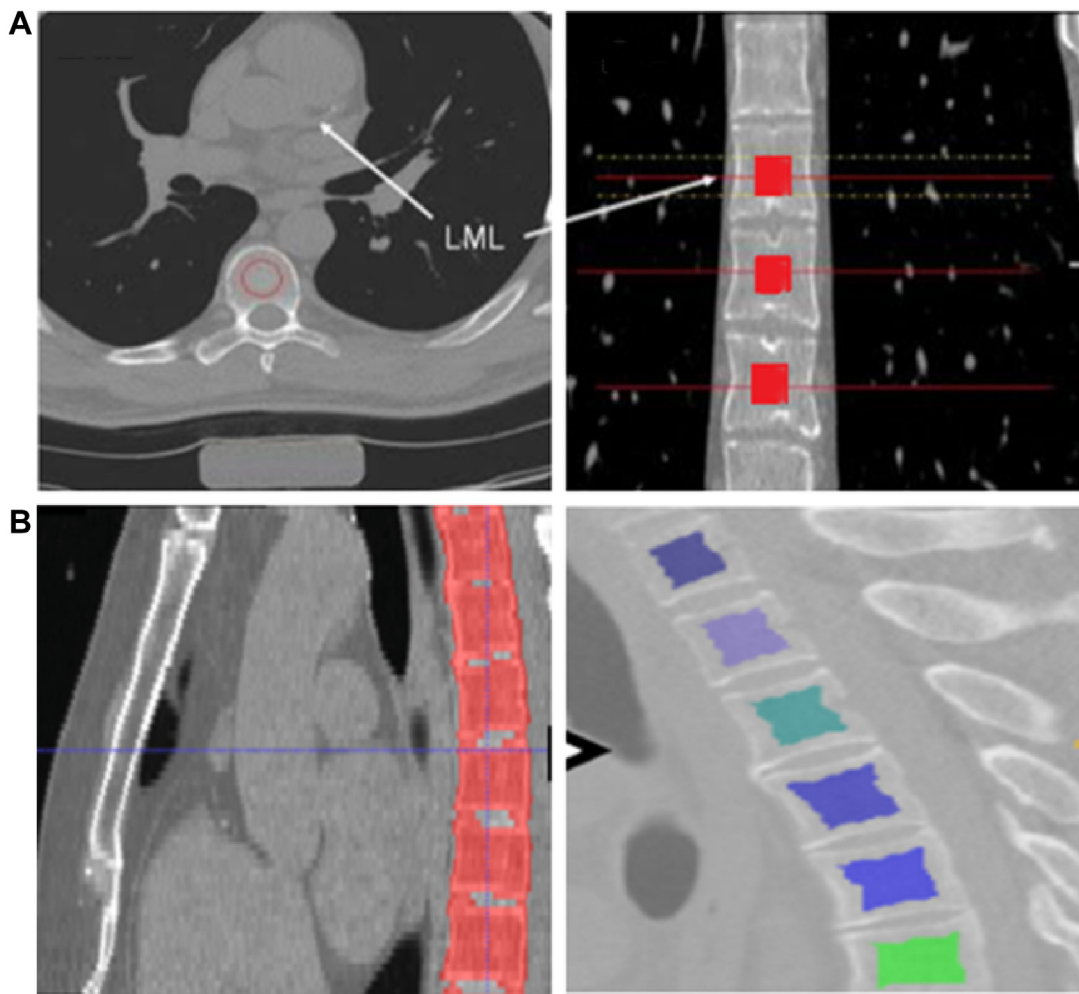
(a) Manual BMD measurement on quantitative CT images. Measurements are outlined by a 10-mm circle on the axial image (left) and indicated by horizontal lines on the sagittal image (right). The 10-mm rods are placed in the middle of the vertebral bodies, depicted as red cylinders in the right image. Measurements are started at the level of the left main coronary artery and proceed caudally. (b) AutoBMD measurement on coronary artery calcium scan. The left image shows the process of vertebral bone segmentation. The right image shows segmentations for the trabecular component of the vertebral body which is used for BMD measurements. BMD = bone mineral density.
